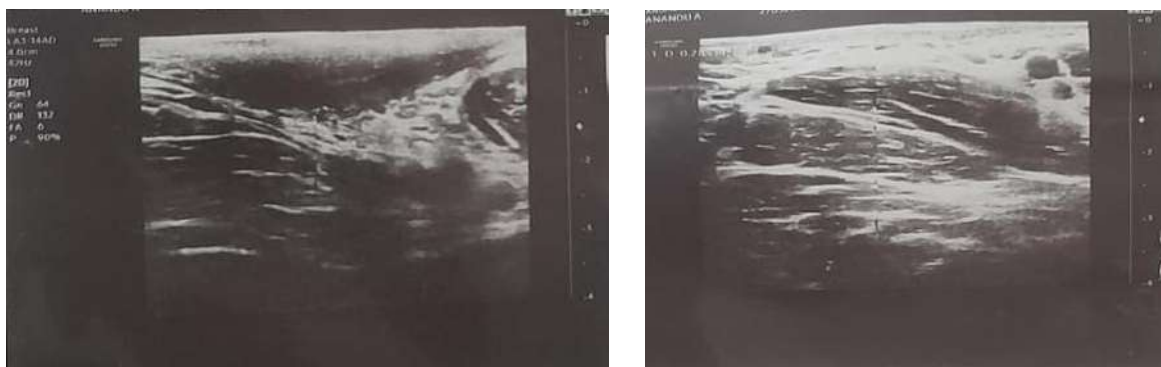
Ultrasonography of the right axilla demonstrating an infected subcutaneous sinus tract with multiple superficial skin openings, adjacent inflammatory foci and reactive axillary lymph nodes.
